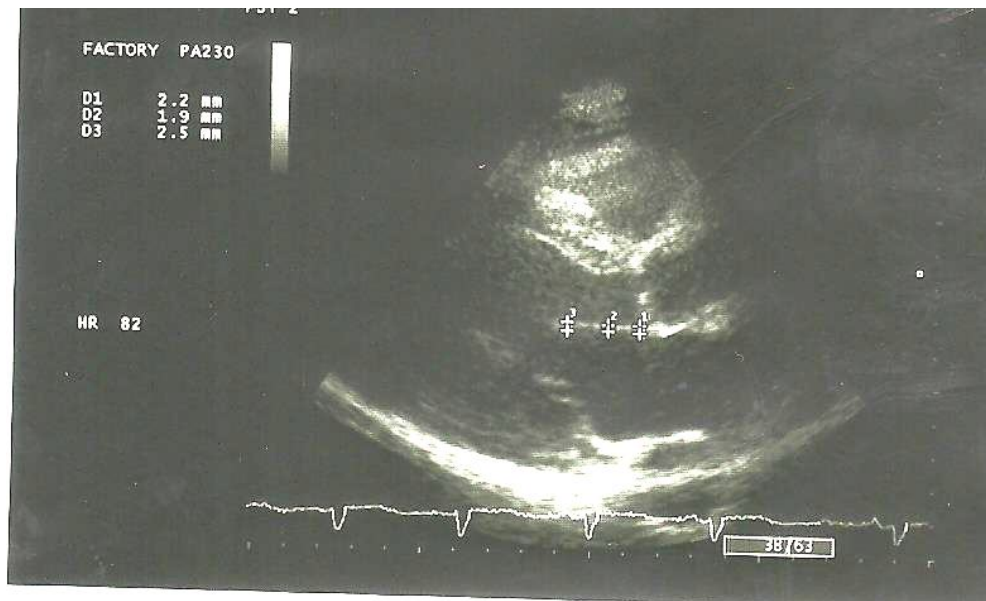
Parasternal long axial view of anterior leaflet.
